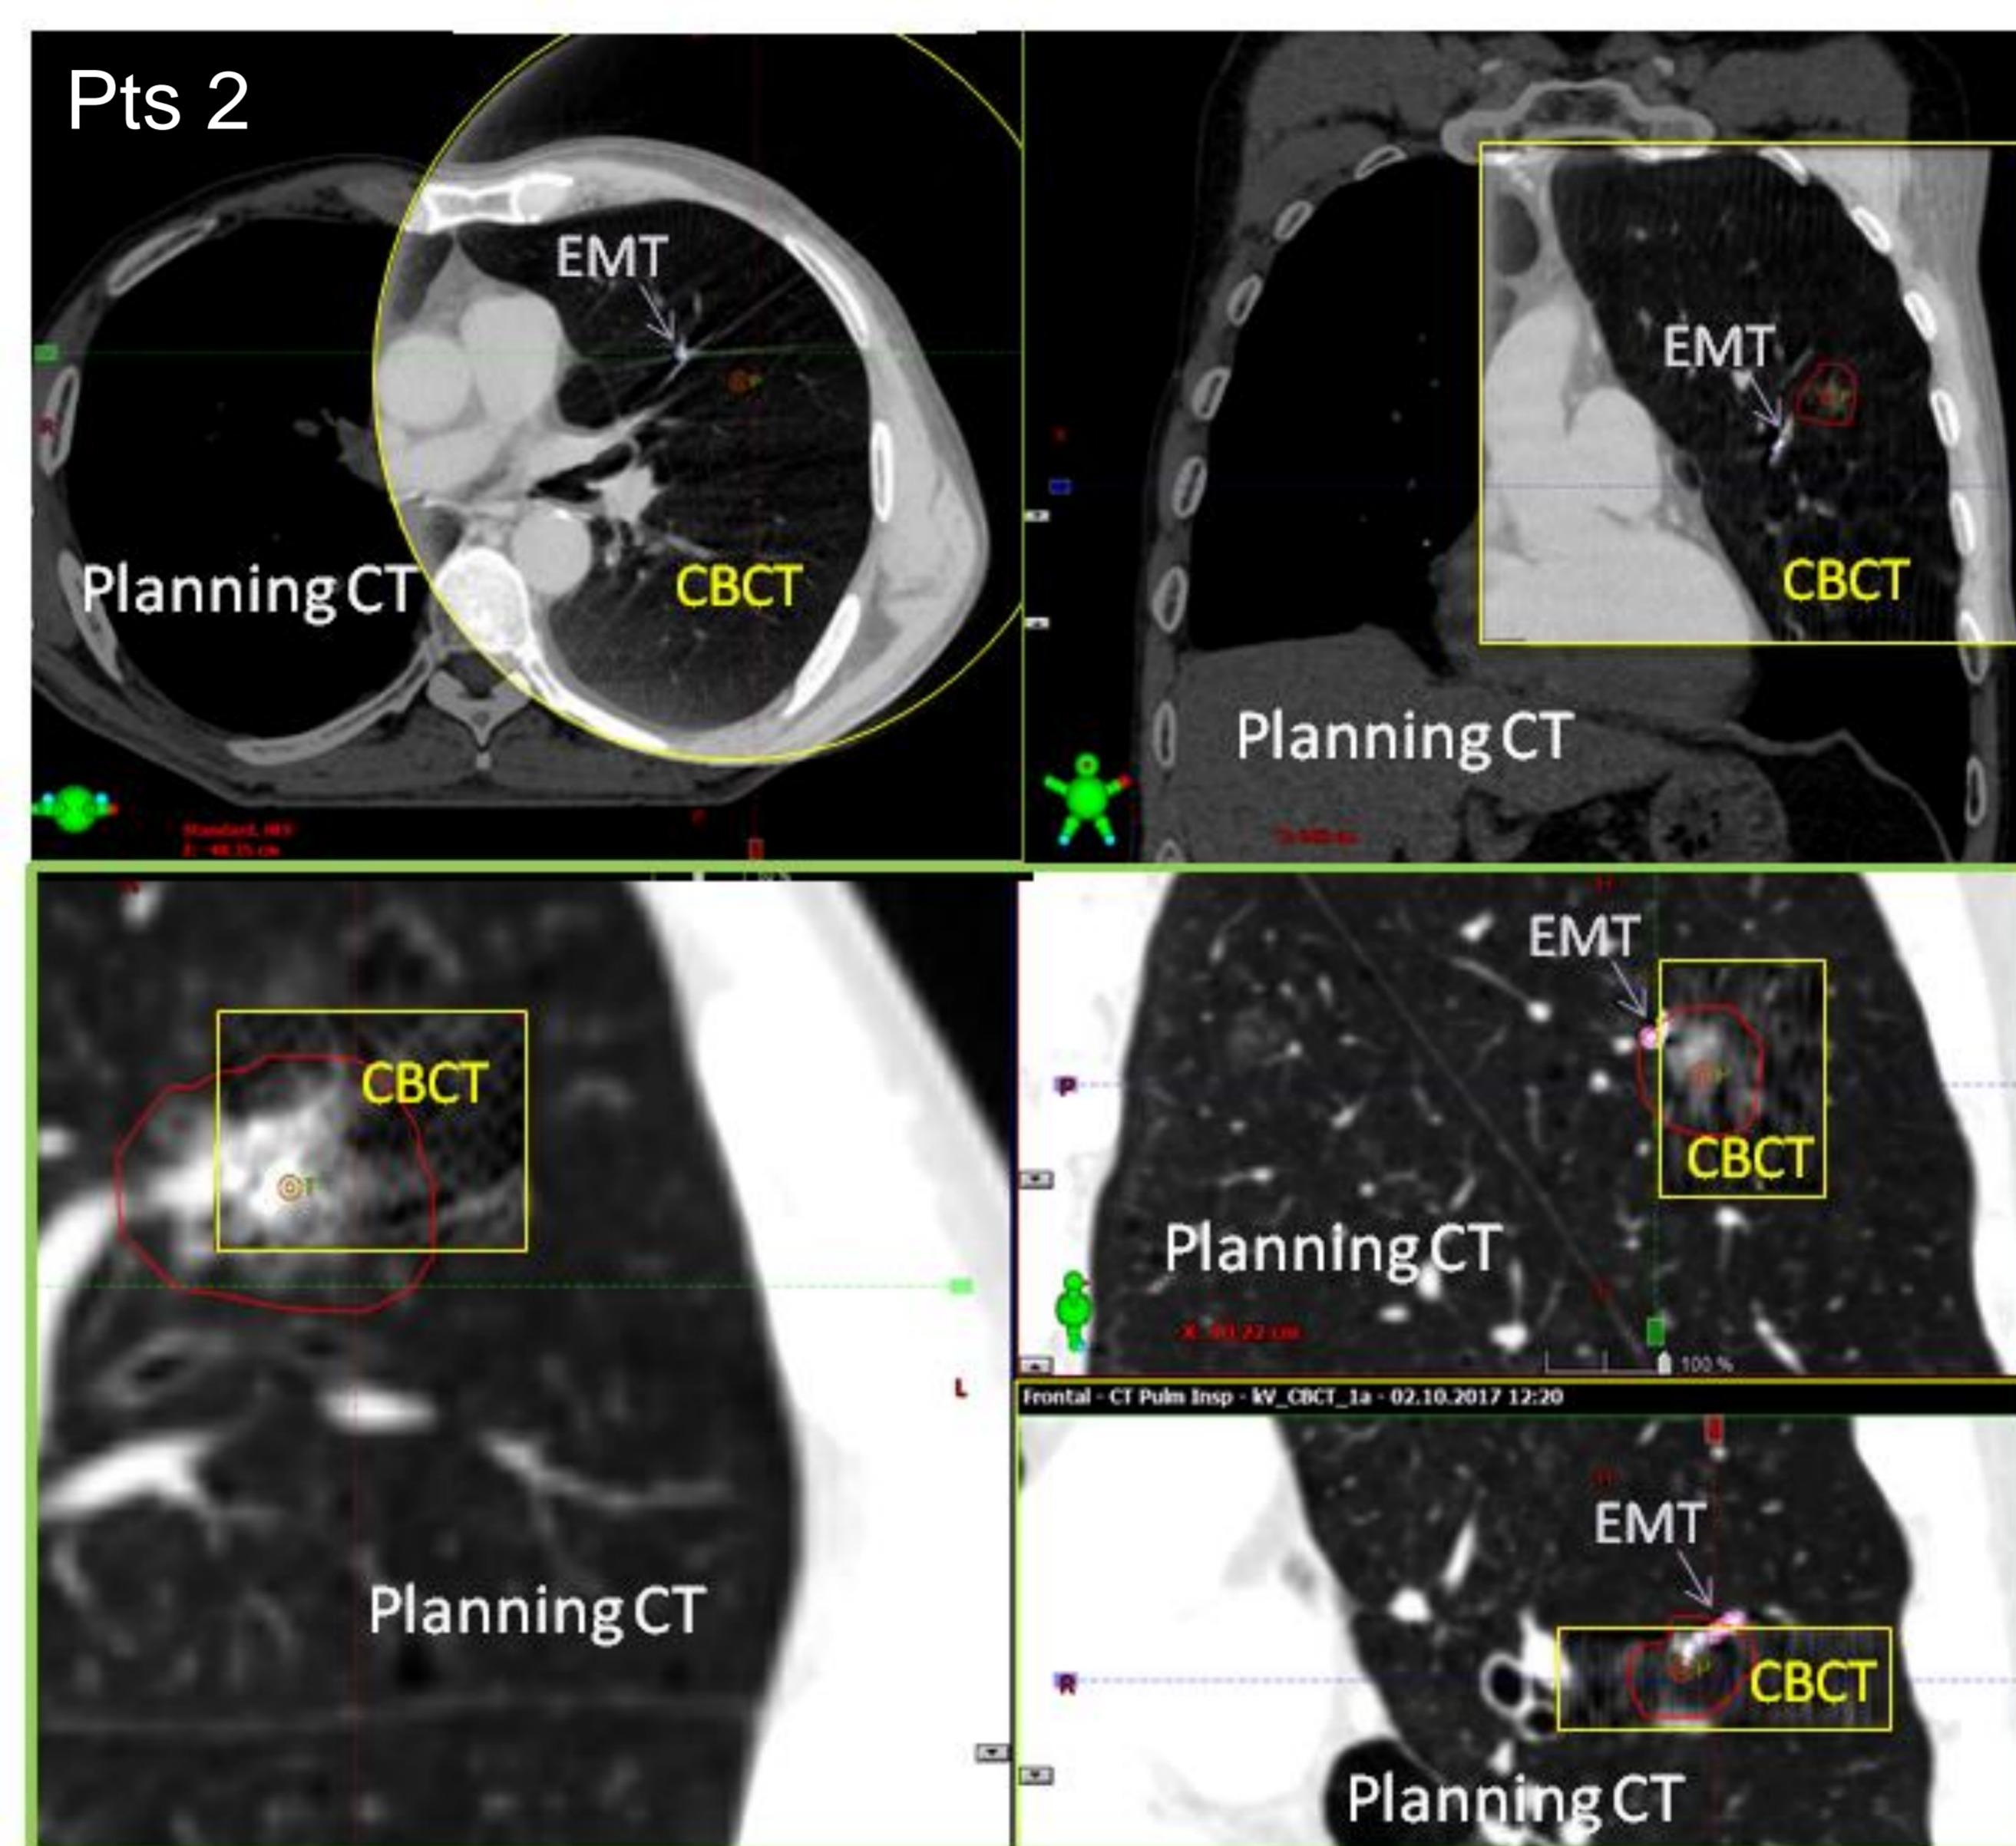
Patient 2 CBCT imaging at linac overlaid with reference CT-scan.
